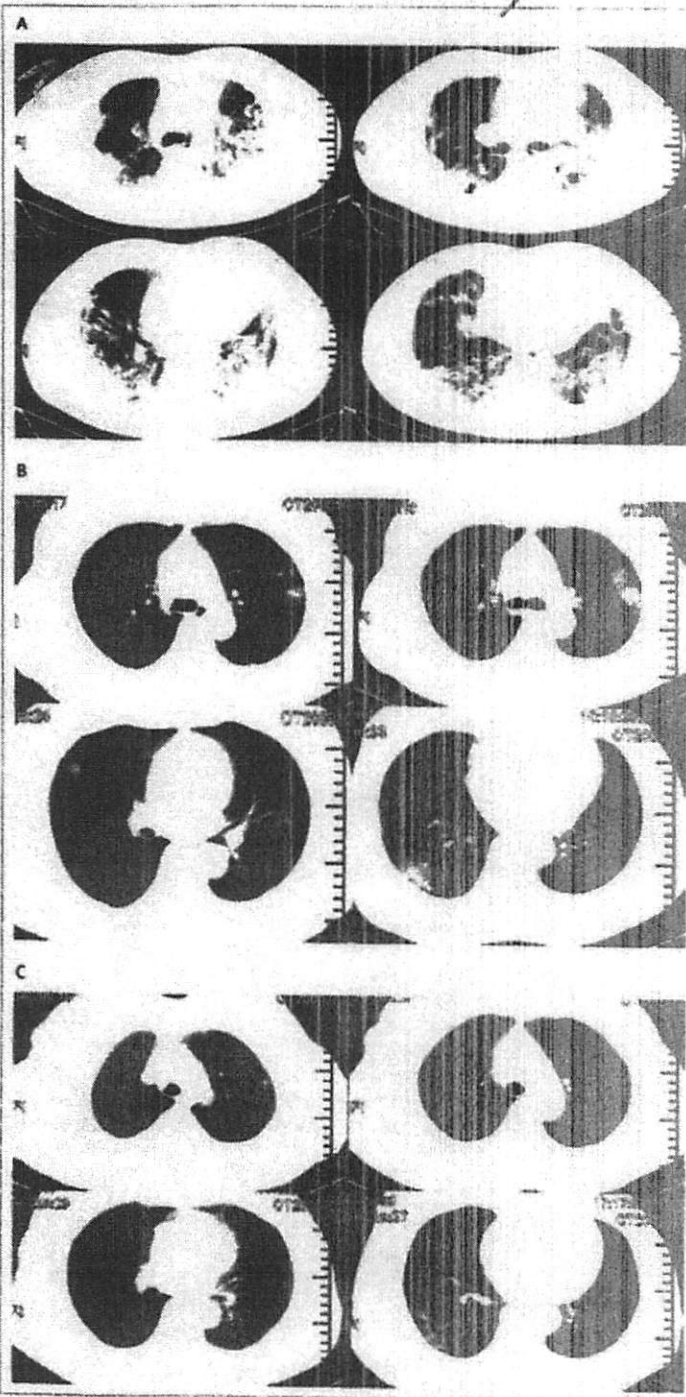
Chest CT images
